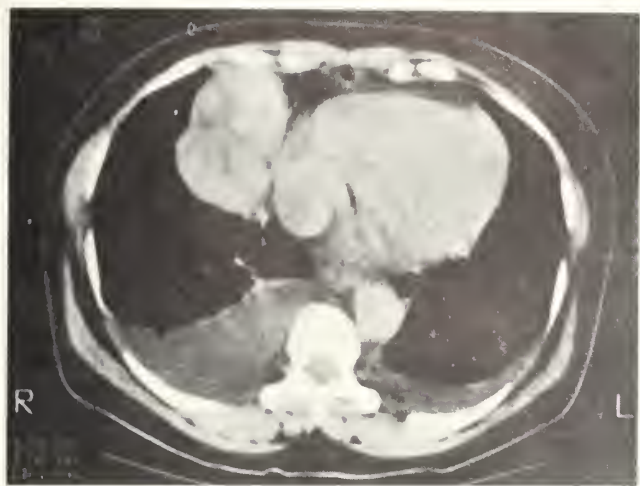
Computed tomography of the chest demonstrates a mediastinal mass attached at its base to the pericardium at the level of the right atrium. No invasion into other intrathoracic structures was present.
